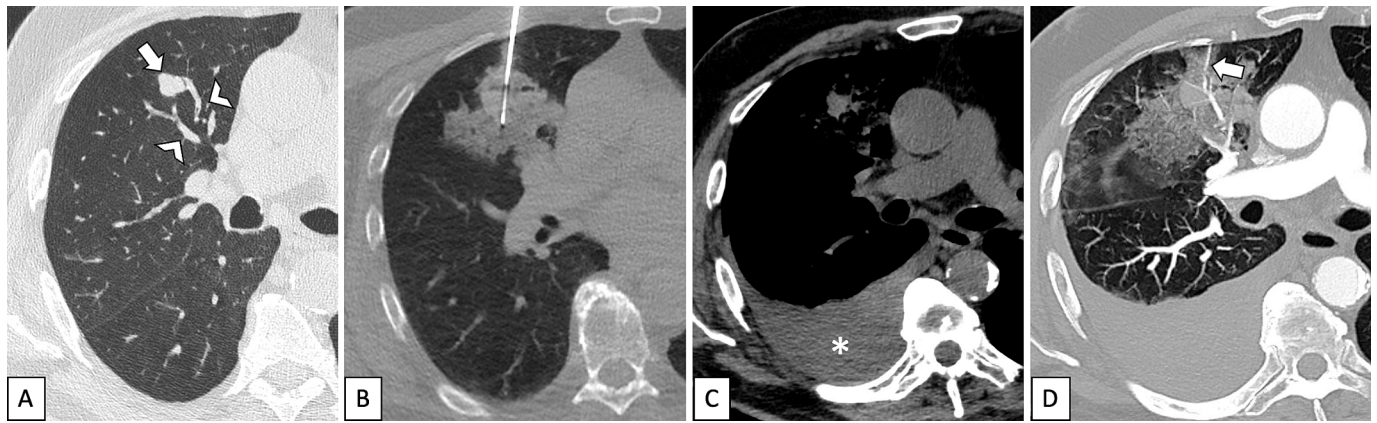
A-D. CT-guided transthoracic core needle biopsy of solid nodule located in the right upper lobe (arrow in A), surrounded by vessels (arrowheads). B. The needle transfixes the lesion and intercepted adjacent vessels, with consequent circumscribed parenchymal hemorrhage. C. After needle removal, a hemothorax rapidly accumulated (asterisk). D. A contrast-enhanced CT was immediately performed to identify the site of bleeding, depicting active blood extravasation along the needle tract (arrow) into the pleural space. The biopsy revealed poorly differentiated non-small cell carcinoma, not otherwise specified.
